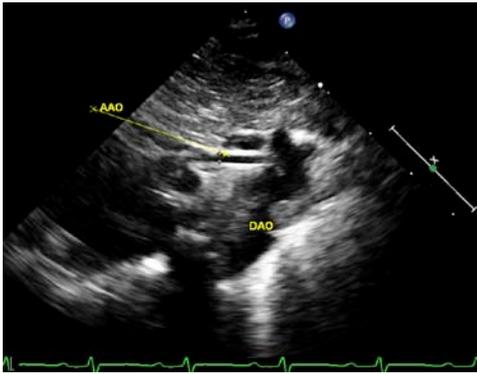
Two dimensional echocardiographic, supra-sternal notch, long-axis view of the aortic arch in a patient with Hypoplastic Left Heart Syndrome. This still frame shows markedly hypoplastic ascending aorta (AAO), serving only to deliver blood in a retrograde fashion to the coronary arteries. The descending aorta (DAO) is tortuous and the appearance is suggestive of aortic coarctation.
